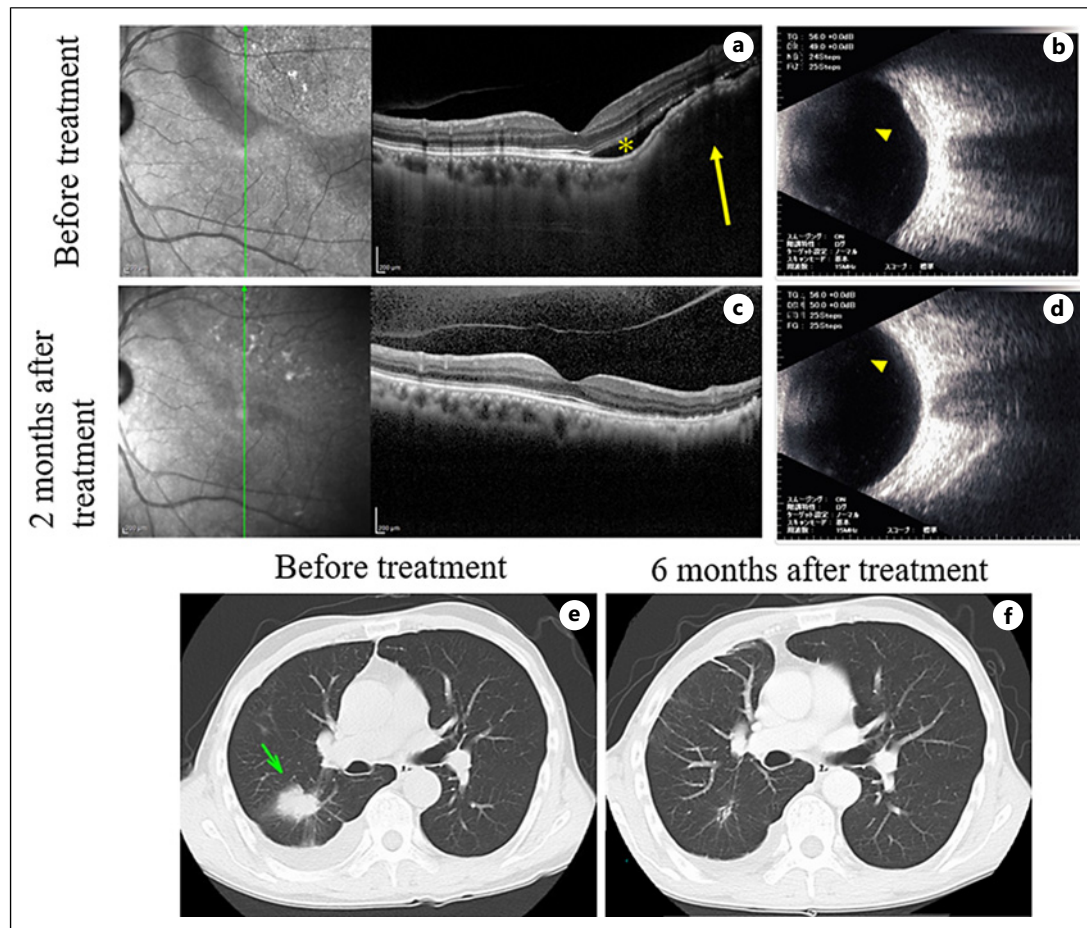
a–d Two months after osimertinib therapy, fundus findings, optical coherence tomography, and B-mode ultrasonography revealed a left choroidal lesion, and subretinal fluid was almost completely gone. e, f The right lower lobe lung cancer had shrunk to about 15 mm in maximum diameter and decreased pleural effusion after 6 months of treatment with osimertinib.
